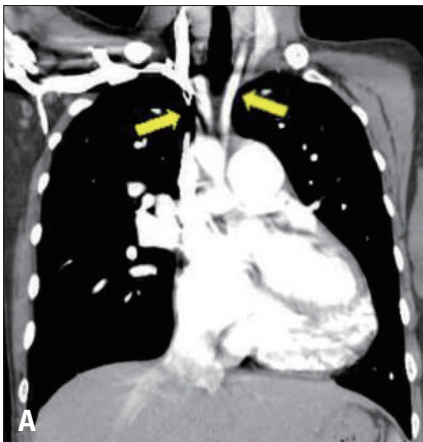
Chest dynamic computed tomography showed the great vessels originated from the arch in the following order, left common carotid artery (right arrow) (A), right common carotid artery (left arrow) (A), right subclavian artery (B), and aberrant left subclavian artery (C). Left subclavian artery originated from descending aortic arch.
